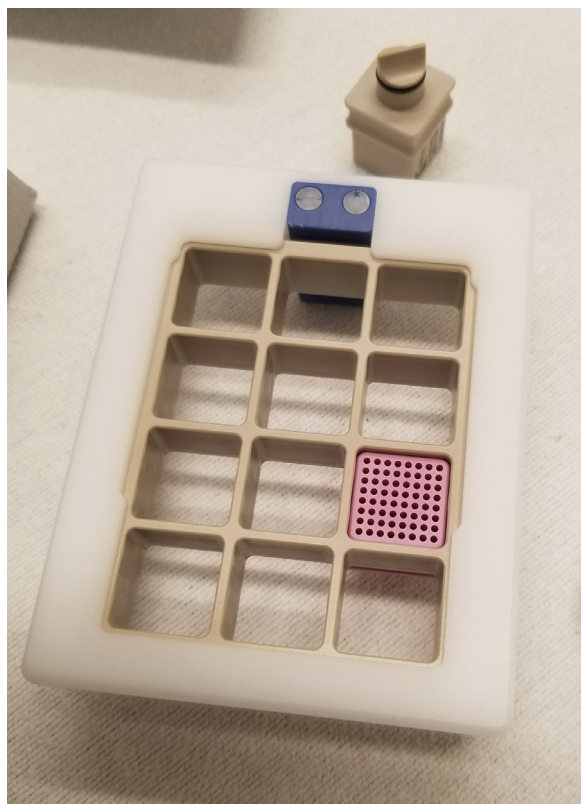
The reusable perineal localizer grid and marker block used during transperineal in-bore MRI biopsy. (Color version of figure is available online.)
